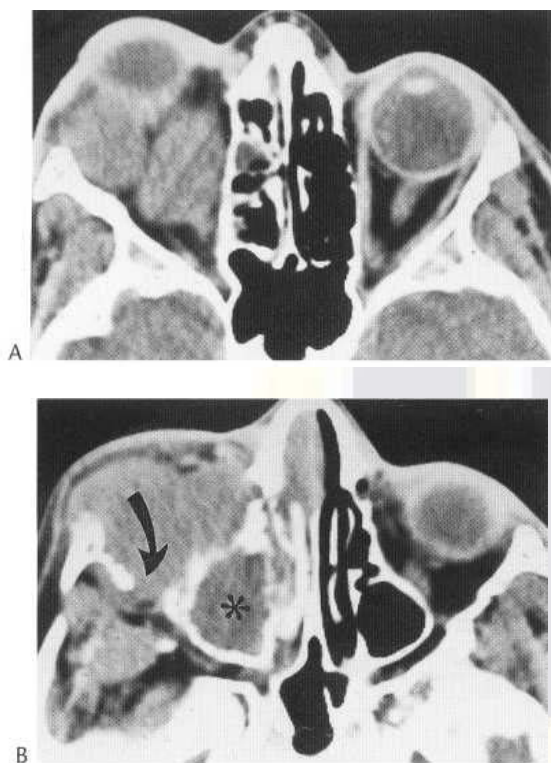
Rhabdomyosarcoma. Contrast-enhanced axial CT image (A) through orbits demonstrates right proptosis due to large, lobular, intra-orbital mass. Image at lower level (B) demonstrates invasion of right maxillary sinus (asterisk) as well as extension through lateral orbital wall (arrow), consistent with the aggressive nature of this tumour. (Case courtesy of Orlando Ortiz, M.D.)
